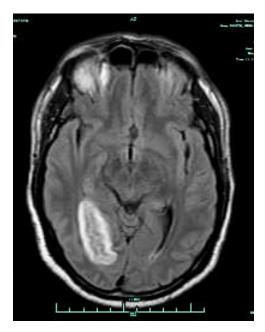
Magnetic Resonance Images: Recovered-dreaming patient (#7)
